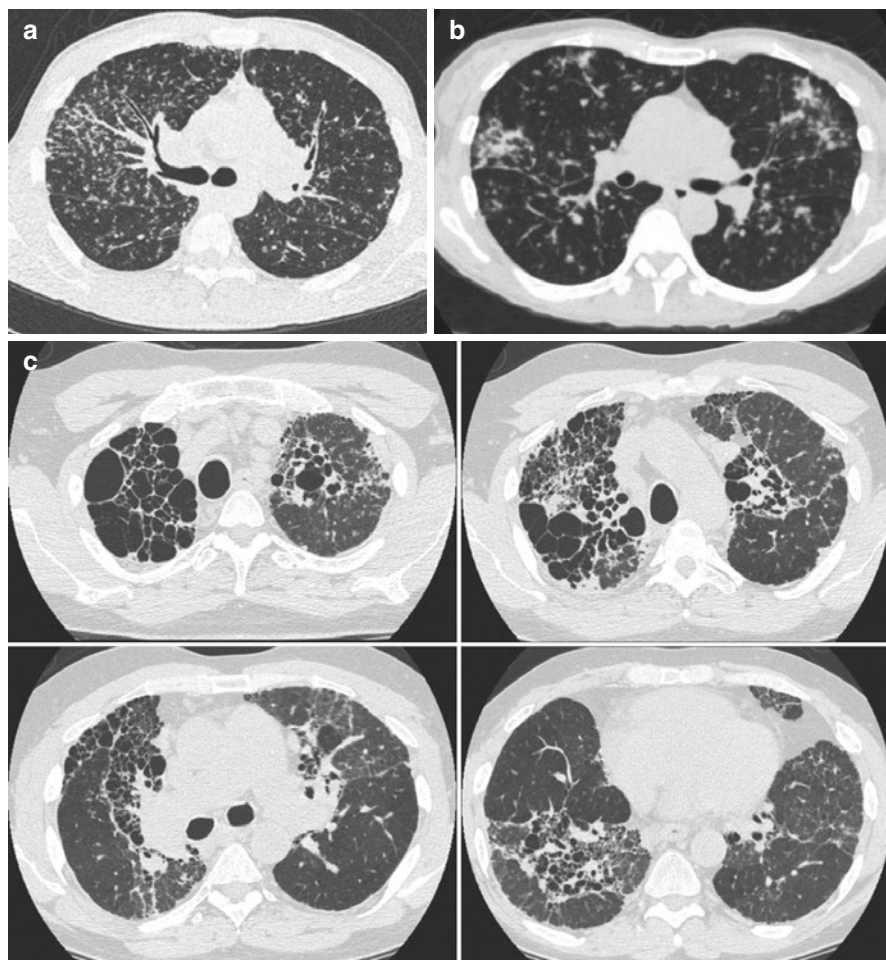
Computed Tomography in Sarcoidosis
